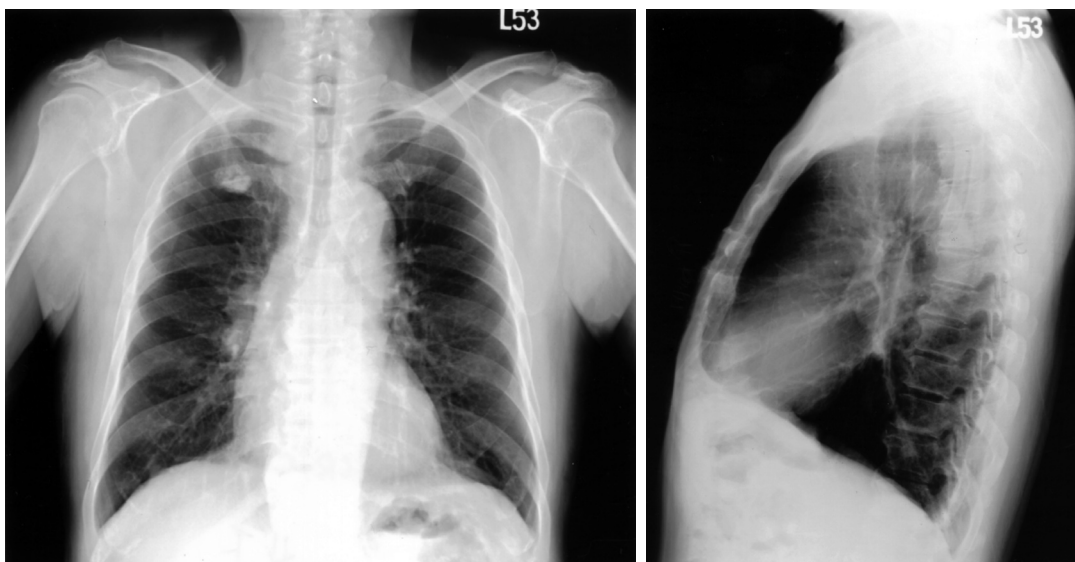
Chest radiograph showing carinal widening and a subcarinal lesion
